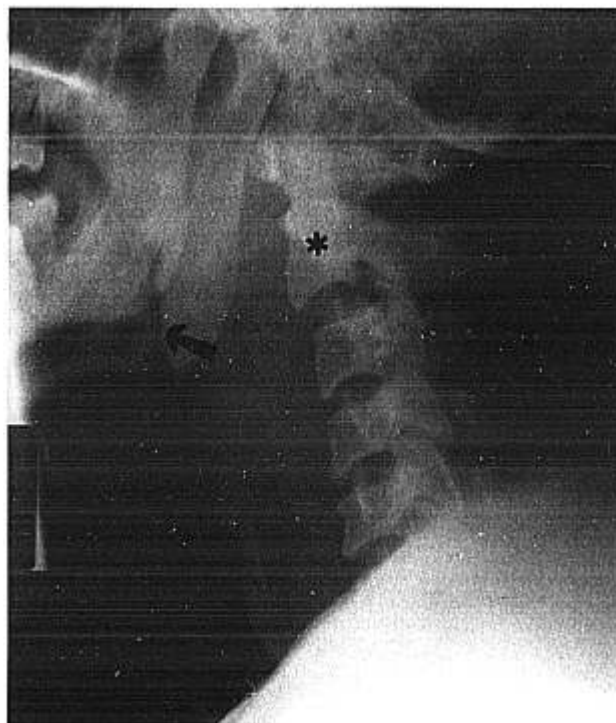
Admission lateral cervical spine radiograph shows marked PSTS (arrow), resulting in partial compromise of the airway. Note also the anterior subluxation of C2 (asterisk) in relation to C3.
